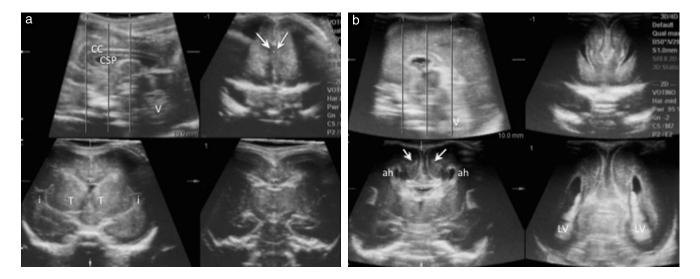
Postmortem ultrasound of fetal brain (tomographic ultrasound imaging of coronal plane). (a) Normal brain from a 22-week fetus, terminated for cystic fibrosis. Images obtained with a transvaginal transducer (RIC 5-9) through the anterior fontanel. In the sagittal plane, can be seen a normal corpus callosum (CC), with normal cavum septi pellucidi (CSP) and vermis of cerebellum (V); in the coronal plane, can be seen a normal midline (arrows), thalami (T) and insulae (i). (b) Corpus callosal agenesis in a 23-week fetus. Images obtained with a linear transducer (RSP 6-16) through the anterior fontanel. In the sagittal plane, the corpus callosum is not visible; in the coronal plane, there is increased separation of the hemispheres with a prominent interhemispheric fissure (arrows). The anterior horns (ah) of the lateral ventricles (LV) are displaced laterally and point superiorly. There is disproportionate enlargement of the occipital horns (colpocephaly) with a teardrop configuration of the lateral ventricles.
